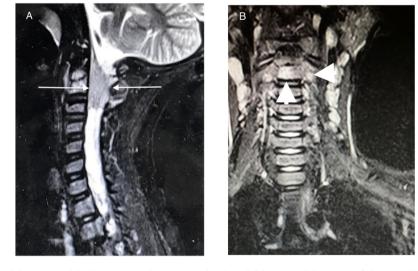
MRI T2 weighted images with *fat suppression*. (a) Sagittal and (b) coronal images of the cervical region demonstrated the intramedullary extension of the lesion (white arrows), and the infiltration of the vertebral body of axis and transverse process spanning (arrowheads).
